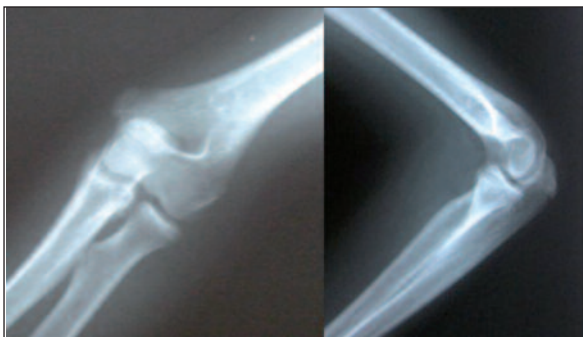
Standart x-rays of the elbow revealed normal findings.
